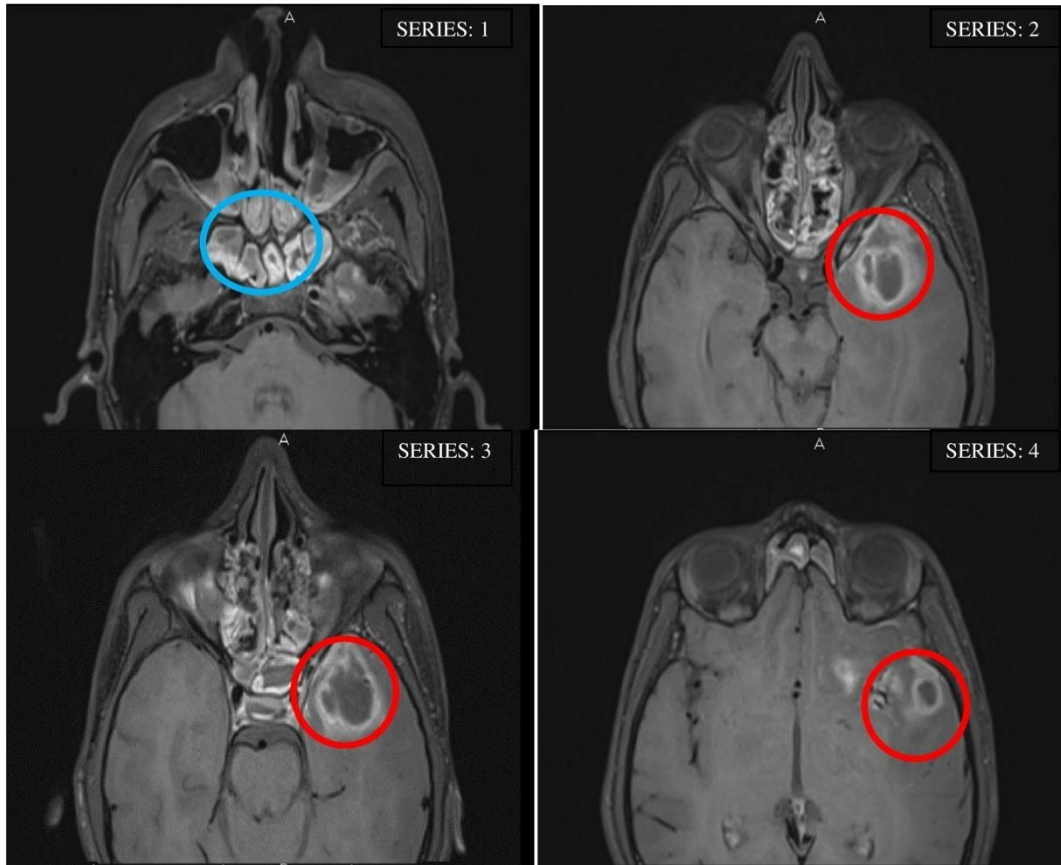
Frontal axis MRI showed left temporal ring enhanced cystitic lesions with edema (marked in red) and enhancement of Sphenoid sinus mucosa (marked in blue) in the patient
